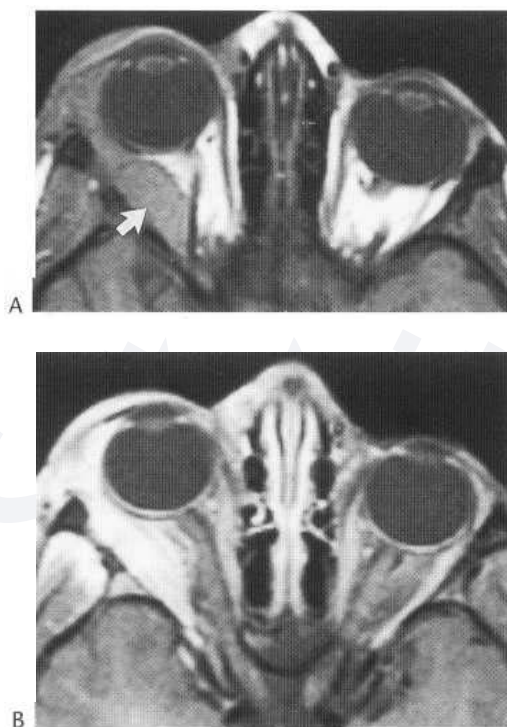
Lymphoma. T-weighted MR image (A) demonstrates proptosis of right globe due to a large intermediate signal intensity lesion that involves the lacrimal fossa and the right lateral rectus muscle (arrow), with extension posteriorly in the extraconal compartment. Postcontrast image (B) demonstrates homogeneous enhancement.
